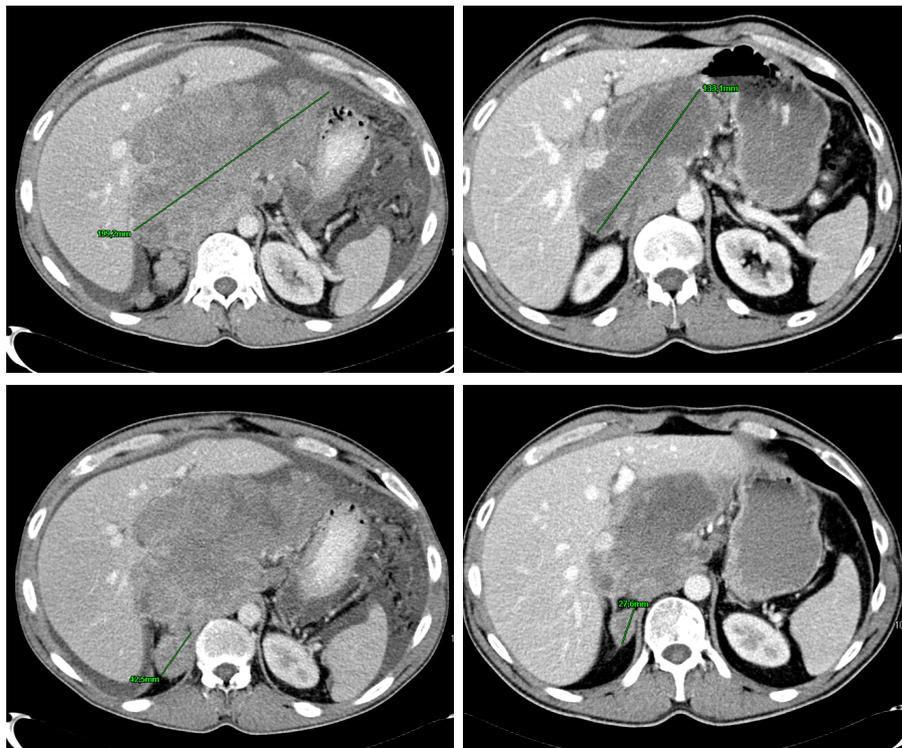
CT images of a melanoma patient treated at the starting dose-level of 750 mg/m² gemcitabine, AUC3 carboplatin and 200 mg BID sorafenib. This patient had a partial response following 2 cycles of treatment, that was confirmed after 4 and 6 cycles of treatment. Left images represent baseline scans, right images scans after 4 cycles (12 weeks) of treatment.
